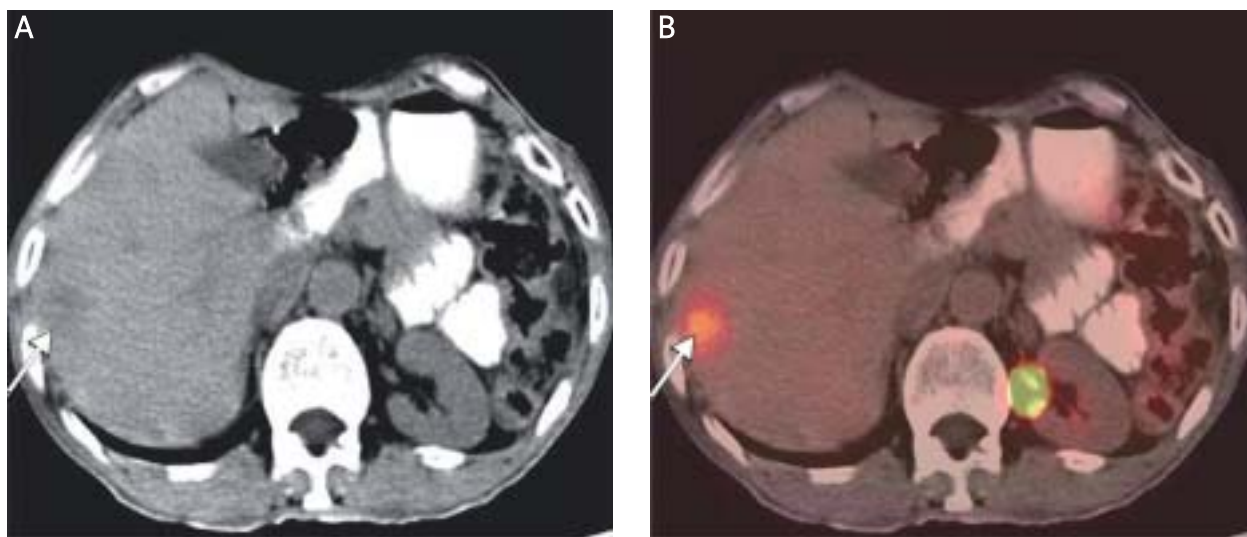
Pretreatment PET-CT scan images. CT scan image (A) shows an ill defined, solid, hypodense mass measuring 2 cm in segment V of liver. PET scan image (B) shows increased FDG uptake with SUV of 7.8 in the same region
